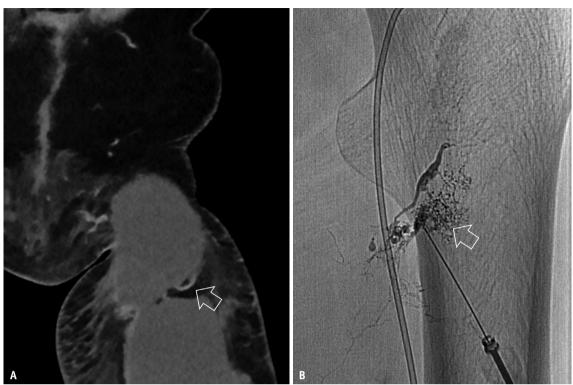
A 67-year-old female with inguinal lymphocele after groin lymph node dissection for vulvar cancer. A. A fractured inguinal lymph node (arrow) is observed next to a large inguinal lymphocele. B. The lymph node (arrow) was accessed under ultrasound guidance and lymph node embolization was performed by injecting diluted glue (N-butyl cyanoacrylate:Lipiodol = 1:3 mixture).
